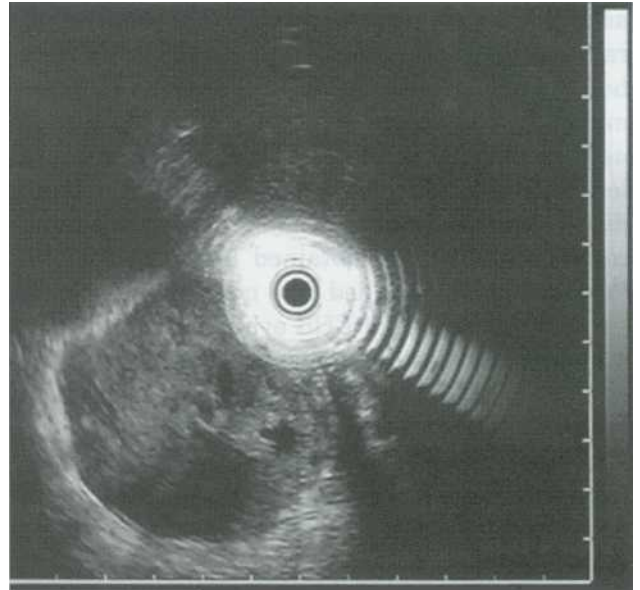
Endoscopic ultrasonographic feature of a malignant gastrointestinal stromal tumor at the stomach. Note the large heterogeneous mass with anechoic spaces and irregular borders suggesting malignancy
